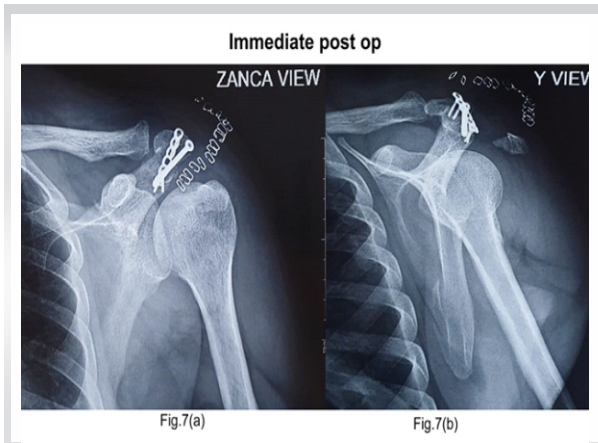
(a and b) Radiographs taken on the 2nd post-operative day.
